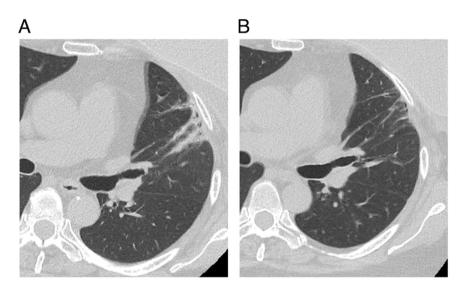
CT findings after immunosuppressive therapy. (A) Day 45. (B) Day 194. Infiltrative shadows improved progressively over time.
